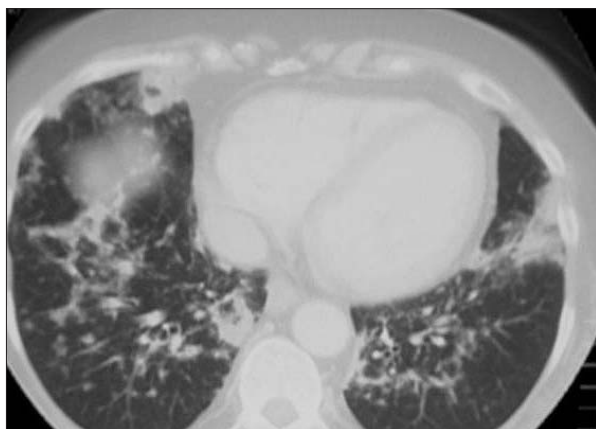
Chest CT (February 2003) bilateral multiple nodules and alveolar consolidation areas.
